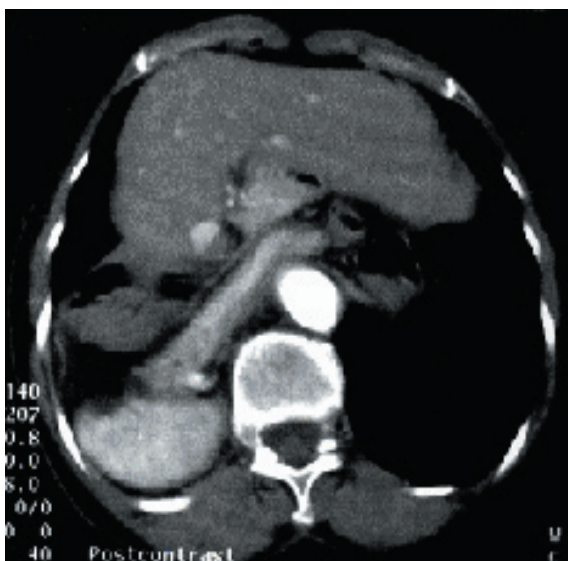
An axial CT image shows the pancreas, loops of bowel and mesenteric fat herniated into the right hemithorax.
